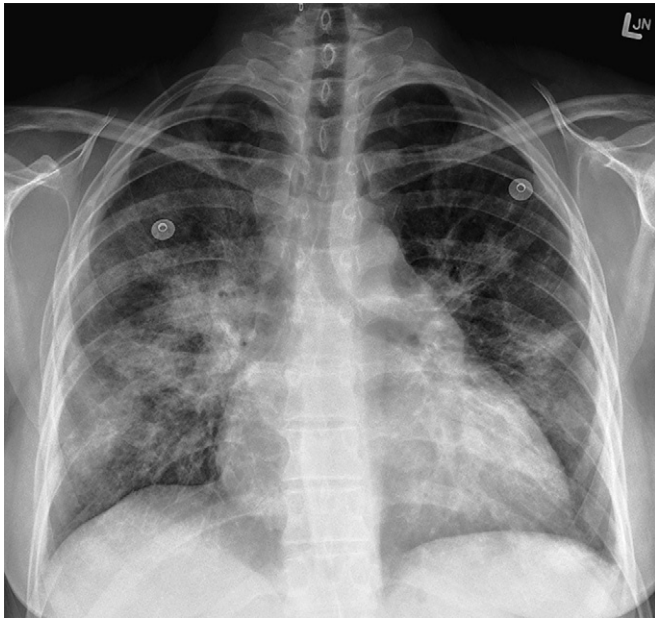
35-year-old female with HIV and S-OIV. Admission postero-anterior chest radiograph 1 week after the onset of symptoms showing bilateral, asymmetric ground-glass and consolidative opacities in a perihilar predominance. Note the hilar and mediastinal lymphadenopathy and the absence of pleural effusions.
